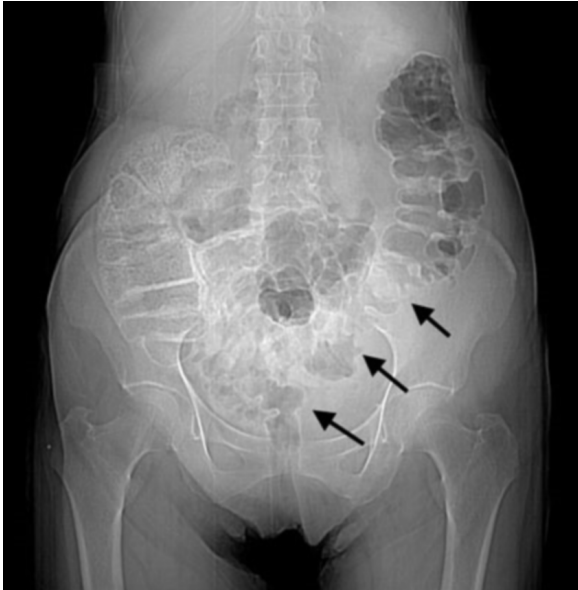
73-year-old woman with abdominal pain. Scout image from the outpatient CT shows displacement of descending colon and proximal sigmoid (arrows) from the normal position in the iliac fossa.
